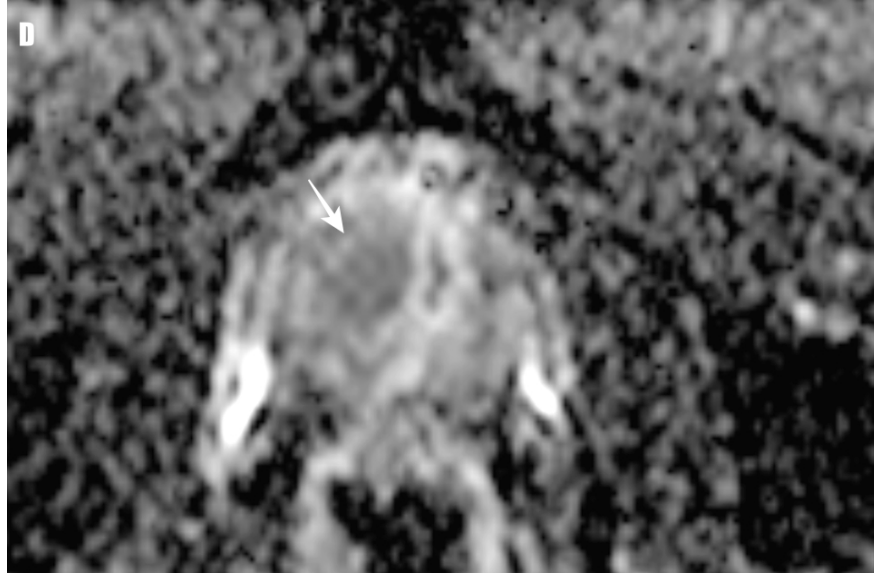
56-year-old man with prostate-specific antigen level of 5.6 ng/mL. Arrows present Prostate Imaging Reporting and Data and System (PI-RADS) category 4 lesions visible in the peripheral zone. A , Axial T2-weighted MR image shows lesion in the left-mid peripheral zone. The dimension of the lesion is 1.0 cm which is consistent with the PI-RADS score of 3 on T2-weighted image. B , C , show that the lesion is hypointense on DWI($b=50 \text{ s/mm}^2$) and hyperintense, on DWI($b=1800 \text{ s/mm}^2$). D , Apparent Diffusion Coefficient map, indicates that the lesion is mildly hypointense, making it PI-RADS score of 3 on DWI. E (precontrast T1-Weighted) and F, Dynamic contrast enhancement MR image shows early enhancement within same location as lesion in A–D with early enhancement for overall PI-RADSv2.1 score of 4. TRUS-guided cognitive MRI fusion biopsy is detected prostate cancer with ISUP 1.
